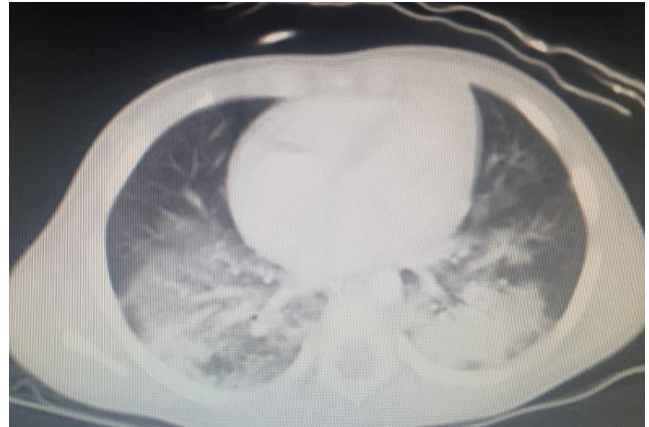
Bilateral pulmonary contusion on CT-Scan
